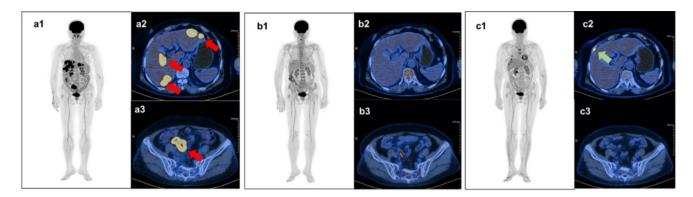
Successive assessment results of a typical patient based on PET/CT imaging. a1, a2, and a3: PET/CT at baseline. The red arrows pointed to the lymphoma sites. b1, b2, and b3: PET/CT after 3 cycles
